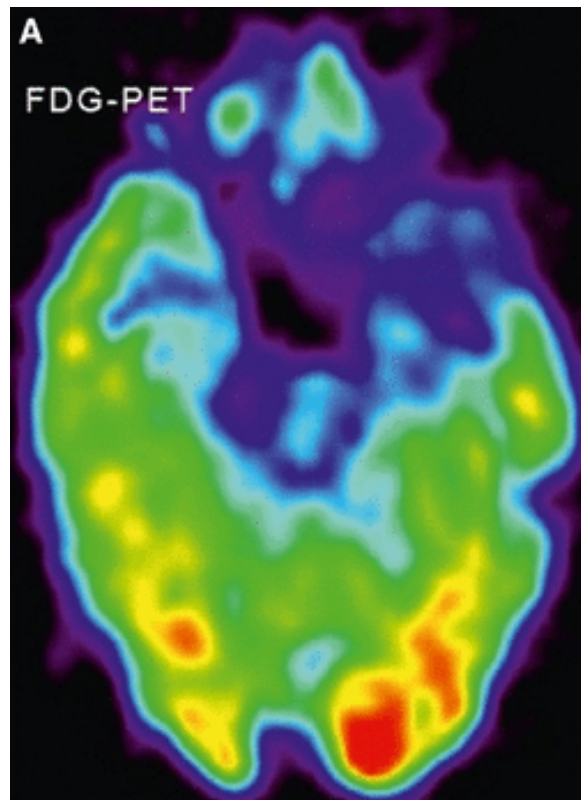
PET findings related to hippocampal sclerosis. (A) Axial scan using 18F-FDG PET. While MRI results appeared normal, FDG-PET revealed significant hypometabolism across the left temporal lobe. From Malmgren & Thom (2012) (100).
